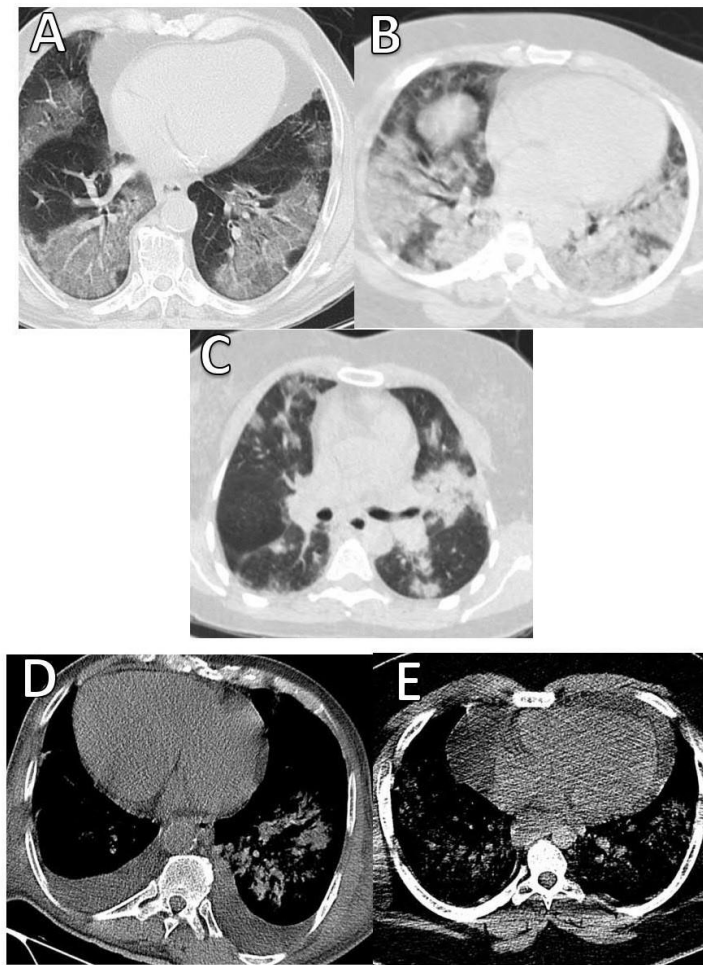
Chest radiography and CT imaging:
